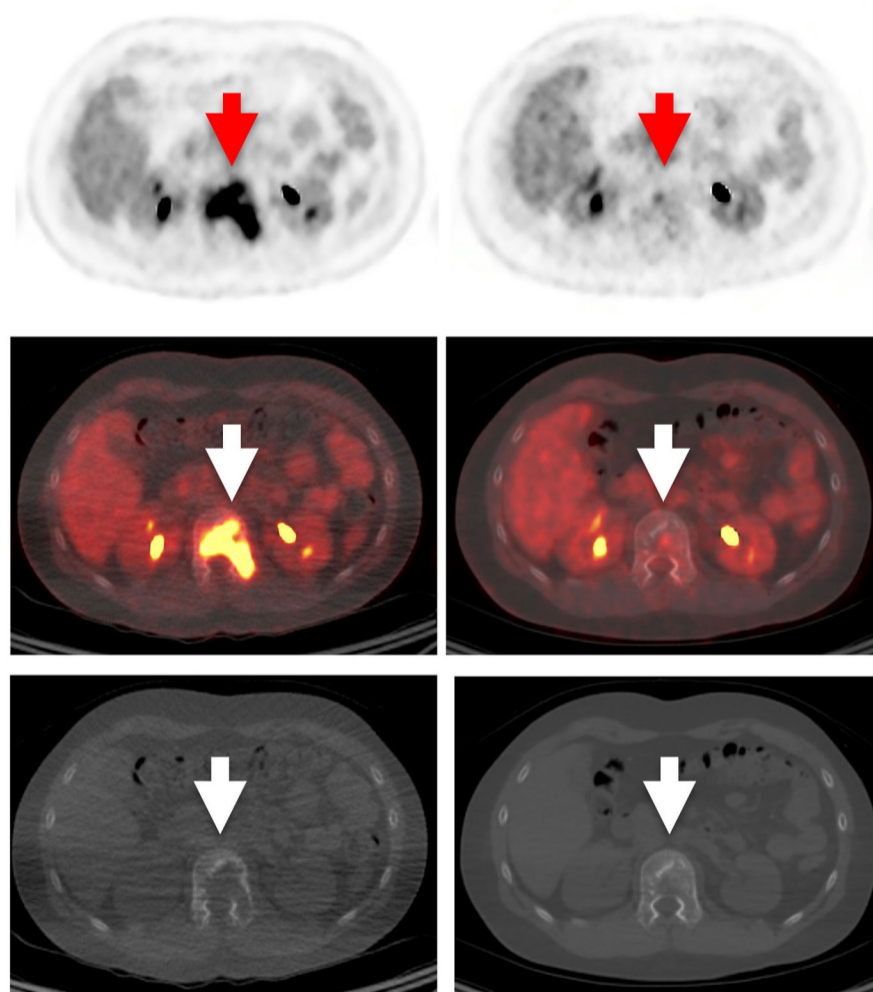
Response to inhibitor as first-line therapy. (A) Graphical summary of all responses achieved in patients treated with an inhibitor as first-line therapy. Response categories are represented by the segments of the doughnut plot. (B) Positron emission tomography (PET) of a 20-month-old female at diagnosis (left panel) with mixed histiocytosis with features of Langerhans cell histiocytosis and juvenile xanthogranuloma, demonstrating extensive disease including fluorodeoxyglucose (FDG)-avid lesions of the calvarium, chest wall, vertebrae, pelvis, and lower extremities, as well as splenomegaly and profound lymphadenopathy involving the neck, chest, abdomen and pelvis. Biopsy was positive for *BRAF*-V600E. Repeat imaging (right panel) following 8 weeks of therapy with trametinib, with marked interval decrease in size and FDG avidity of bony lesions, decrease in splenomegaly and marked improvement in lymphadenopathy throughout. (C) PET (upper and middle rows) and computed tomography (bottom row) of a 12-year-old male at diagnosis (left frames in each row) of multifocal bone LCH demonstrating a large bony lesion involving the L1 vertebral body, with a SUVmax value of 15. Repeat imaging (right frames) performed following 6 weeks of therapy with trametinib shows minimal FDG uptake and marked improvement of the vertebral lesion. NAD: no active disease; CNS: central nervous system; DI: diabetes insipidus.
